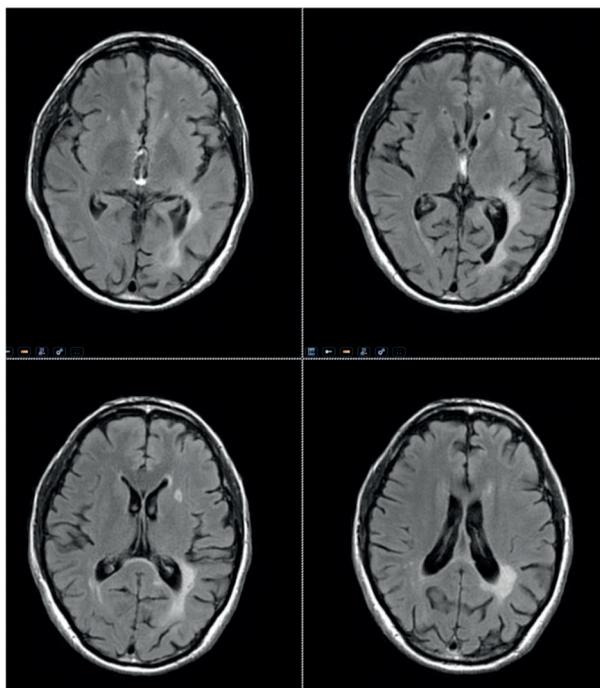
Brain MRI at 4 months-follow-up.
